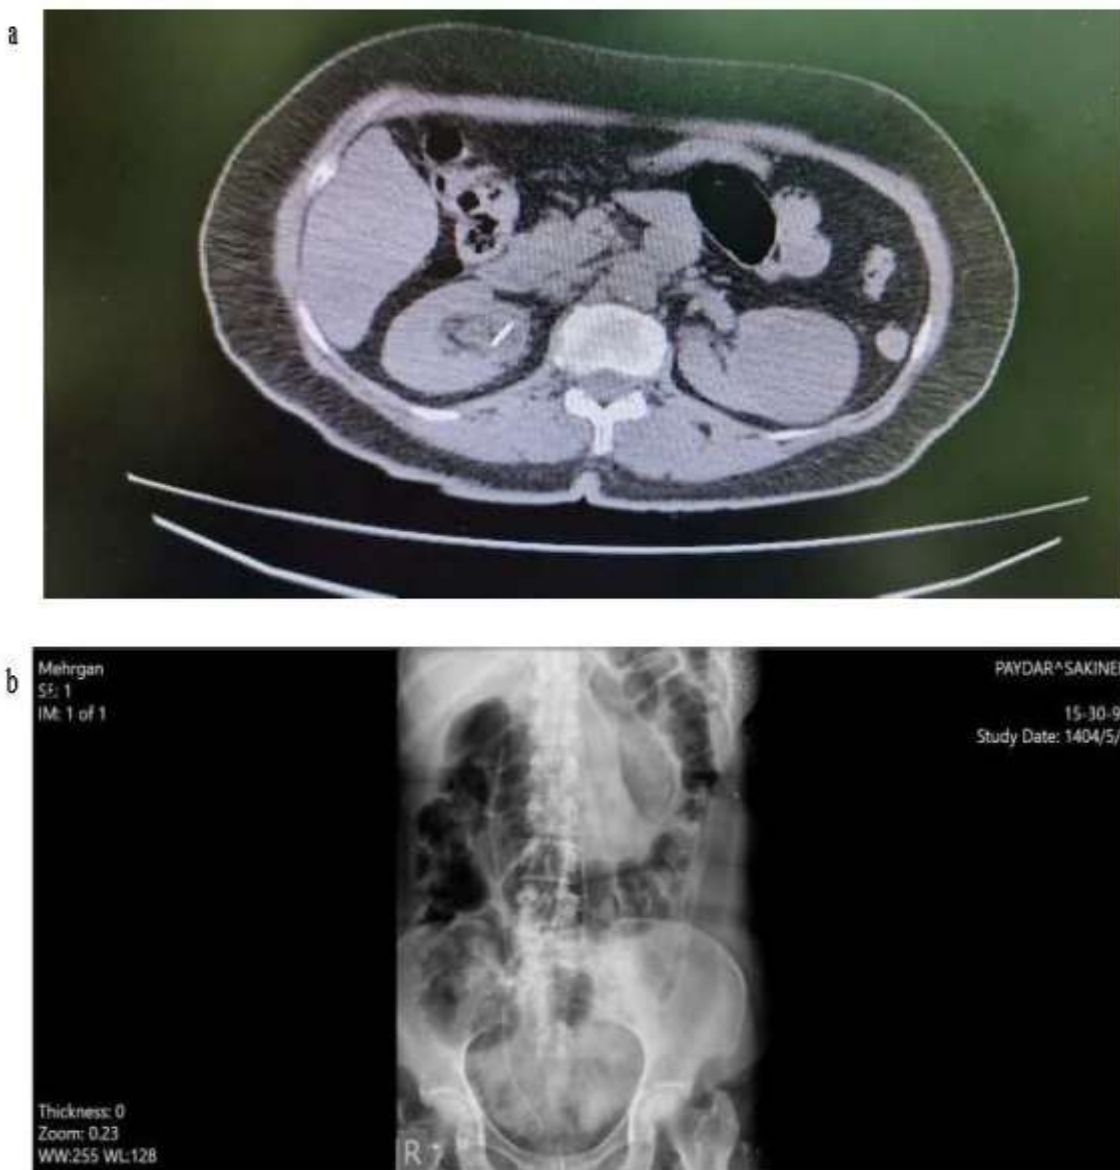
Postoperative CT (1 Month): no residual component of renal pelvis lesion. Double J Stent is observed in the pelvis
